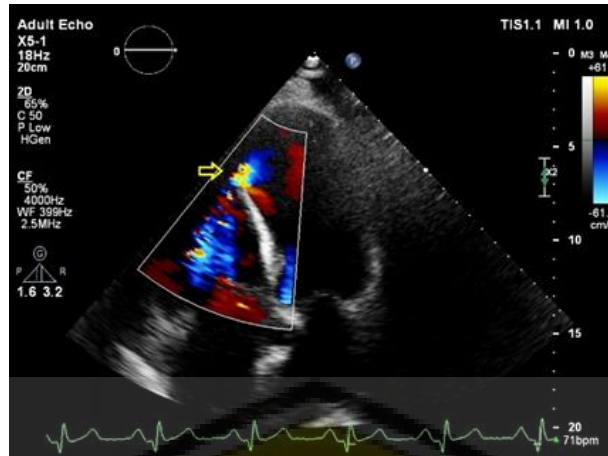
Four chamber echocardiography showed the presence of a VSR type with a diameter of 0.98 cm and the left ventricular ejection fraction of 48%.
